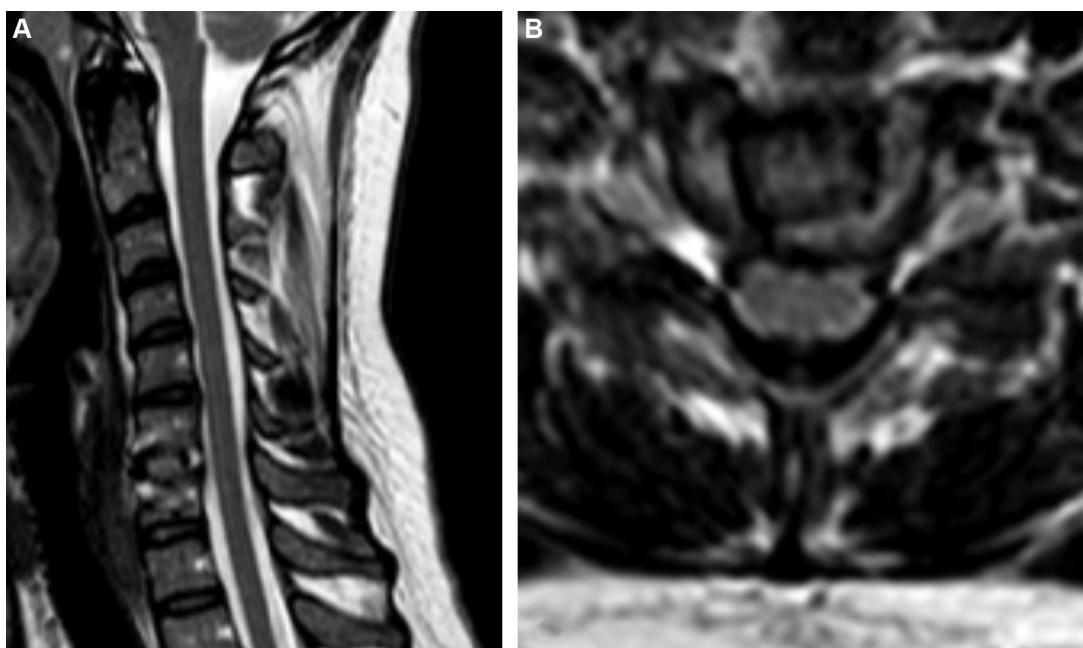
MRI of the spinal cord, T2-weighted sequence, on day 15 after surgery: C6–C7 cage and absence of spinal cord abnormalities on the sagittal (A) and axial (B) images.
